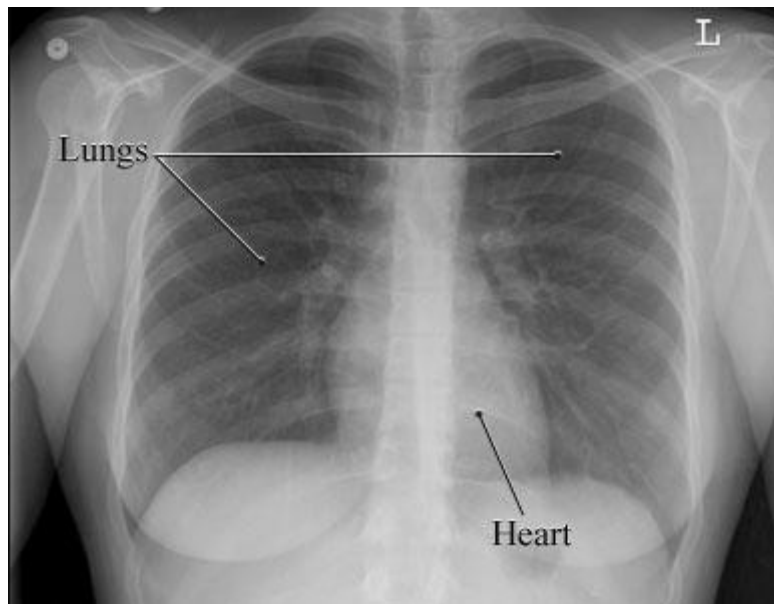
Chest X-ray showing the lungs and the heart (SVH, 2017).
